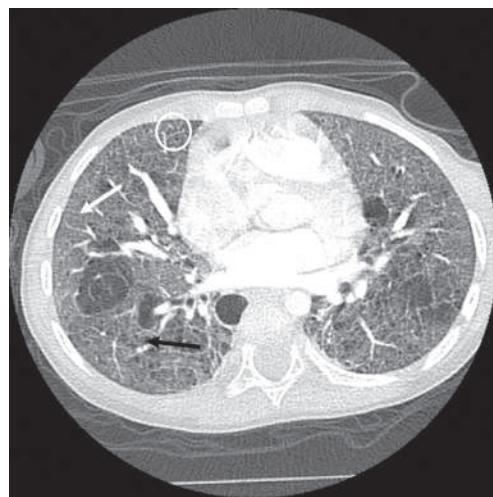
Chest CT from a 2-year-old with a disorder of surfactant metabolism from pathogenic variants in ABCA3. Note the ground-glass opacities (white arrow), septal thickening (circle), and early cyst formation (black arrow). (Courtesy R. Paul Guillerman, MD.)
